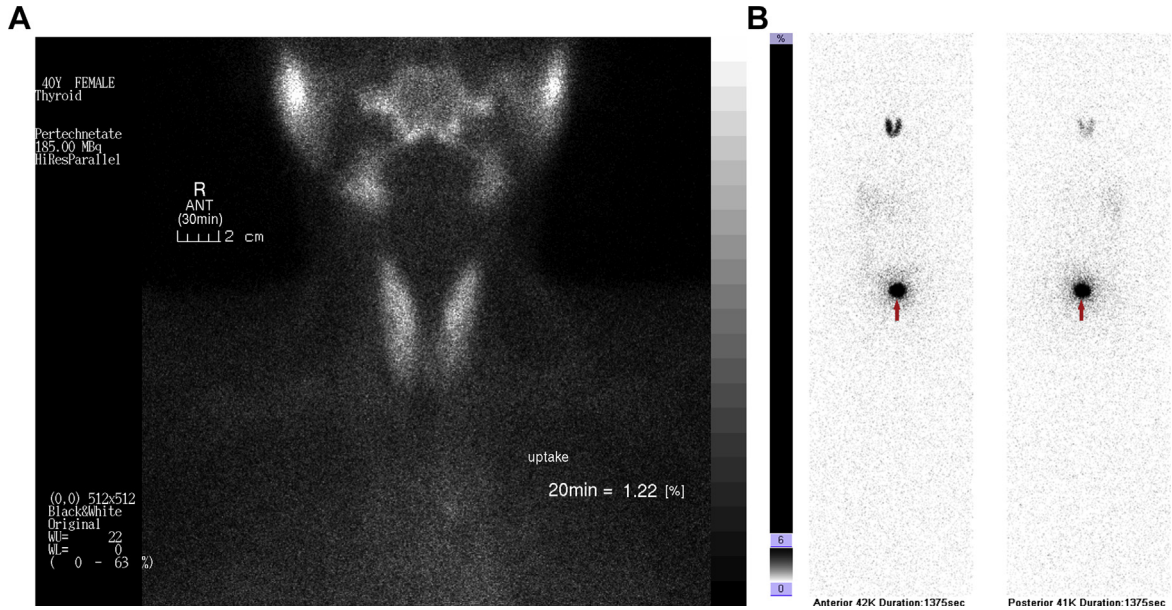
(A) ^{99m}Tc thyroid scintigraphy shows no abnormal uptake to the thyroid; (B) ^{123}I whole-body scintigraphy shows a low radioactive iodine uptake to the thyroid gland and a high iodine level in the left pelvic space.
